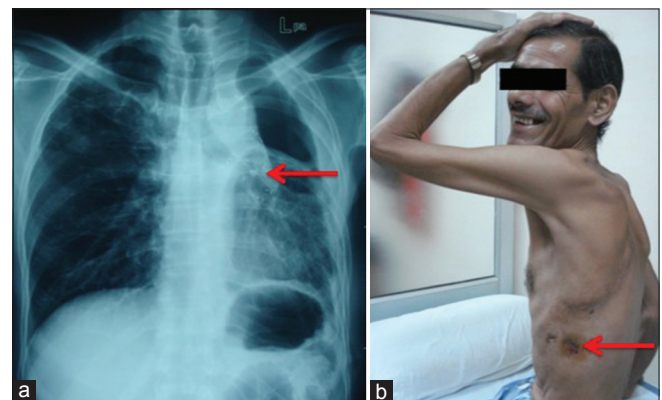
(a) Chest radiograph 1 week after covered Self-expandable metallic stent (SEMS) placement in patient 4. (b) Healed pleurocutaneous fistula in patient 4 after bronchopleural fistulae closure
